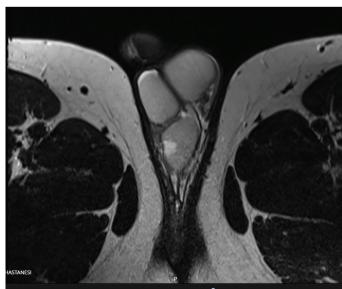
Twice testes in the MRI image MRI: Magnetic resonance imaging
